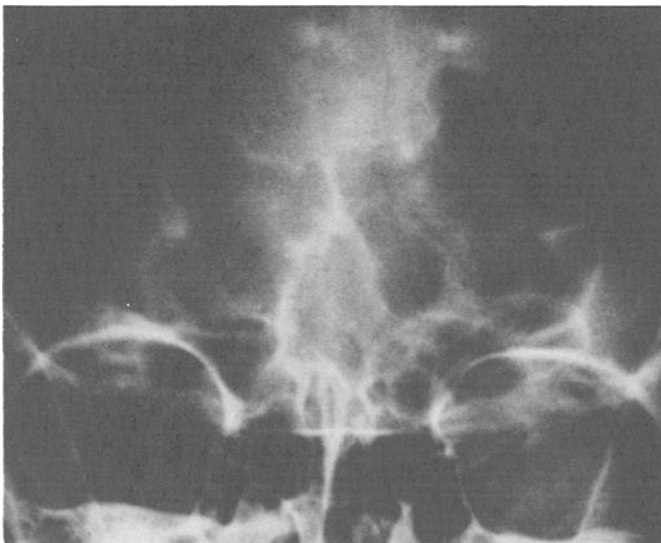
Case 3: radiograph made six years before the victim's death, revealing highly characteristic (especially the left side) and extensive frontal sinuses.
